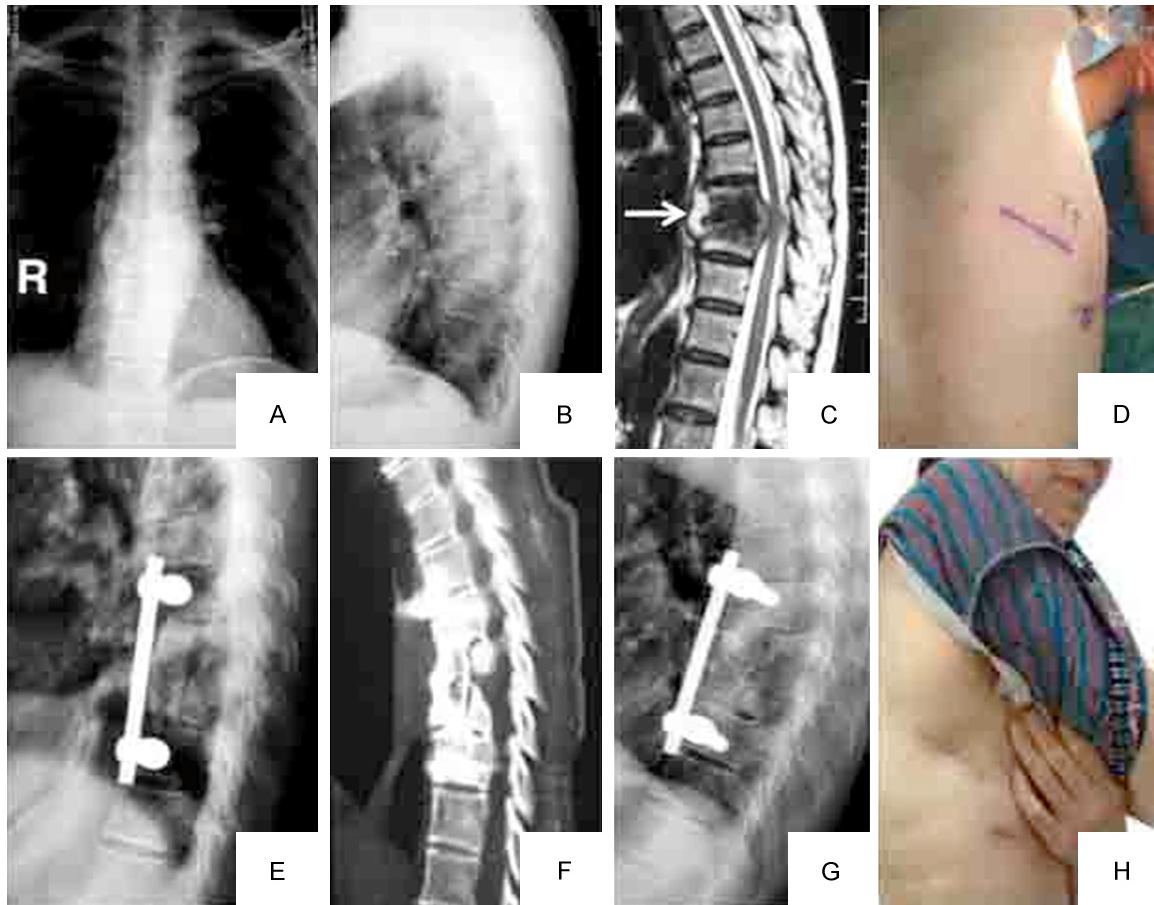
A 53-year-old female with T8-9 tuberculosis underwent thoracoscopic-assisted anterior debridement, iliac bone autograft, and fixation. A, B: Anteroposterior (AP) X-ray shows a paraspinous shadow, and a lateral plain radiograph demonstrates a narrowed disc space at T8-9 and a kyphotic angle of 31.4° ; C: MRI demonstrates vertebral destruction and paravertebral and epidural abscess with compression of the spinal cord (white arrow); D: A 3-4 cm skin incision was made above the target vertebrae, and the patient is in the lateral decubitus position; E: Postoperative lateral plain lateral radiograph shows that there is a normal sagittal alignment of the thoracic spine, and the kyphosis angle measures 15.5° ; F: Computed tomography (CT) scan of the sagittal plane demonstrates a solid fusion at 6-month follow-up; G: Postoperative plain lateral radiograph at final follow-up shows that there was no fixation failure and obvious correction loss. H: Postoperative clinical photograph demonstrates the size of the skin incision.
